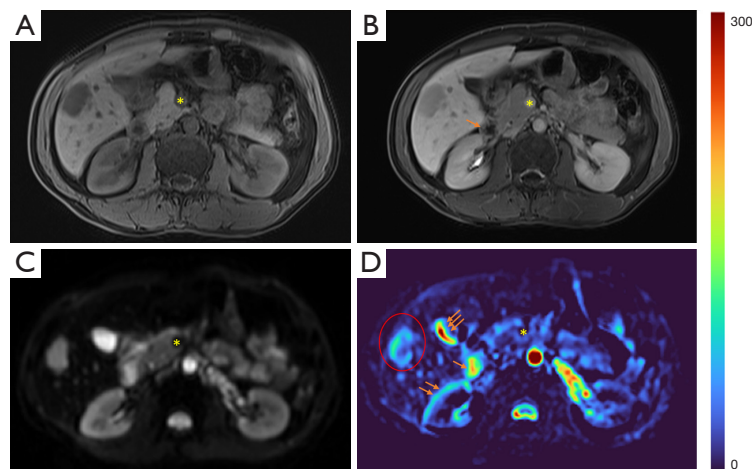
An example of liver DDVD map with a metastatic tumor from nasopharyngeal carcinoma. DDVD map is computed from $b=0$ and $b=10$ s/mm² DW images. Tumor (red circle) appears higher perfusion relative to adjacent liver. (A) T1-weighted anatomical image; (B) gadolinium enhanced T1-weighted image; (C) $b=0$ s/mm² DW image; (D) DDVD map. *, superior mesenteric artery shows flow-related signal void on DW image (C) and DDVD map (D). Single arrow denotes duodenum showing high signal on DDVD map which is caused by the fluid in the lumen and duodenum peristalsis during the DW imaging. This is a common artifact of gastrointestinal tract. Double arrows for right kidney border and triple arrows for gallbladder denote artifacts due to misalignment between $b=0$ and $b=10$ s/mm² images. Note that right renal veins are well shown with high value on DDVD map. CSF commonly shows high value on DDVD map. DDVD, diffusion-derived vessel density; DW, diffusion weighted; CSF, cerebrospinal fluid.
